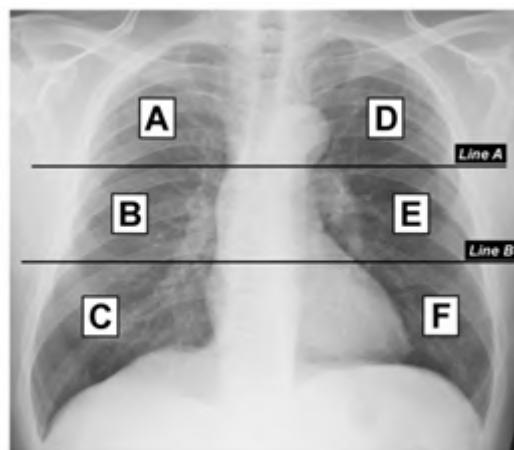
The 6 lung divisions on an anterior chest radiograph. A line is drawn from the inferior wall of the aortic arch. Line B is drawn from the inferior wall of the pulmonary vein. A and D are the upper zone, B and E are the middle zone, and C and F are the lower zone.¹³
